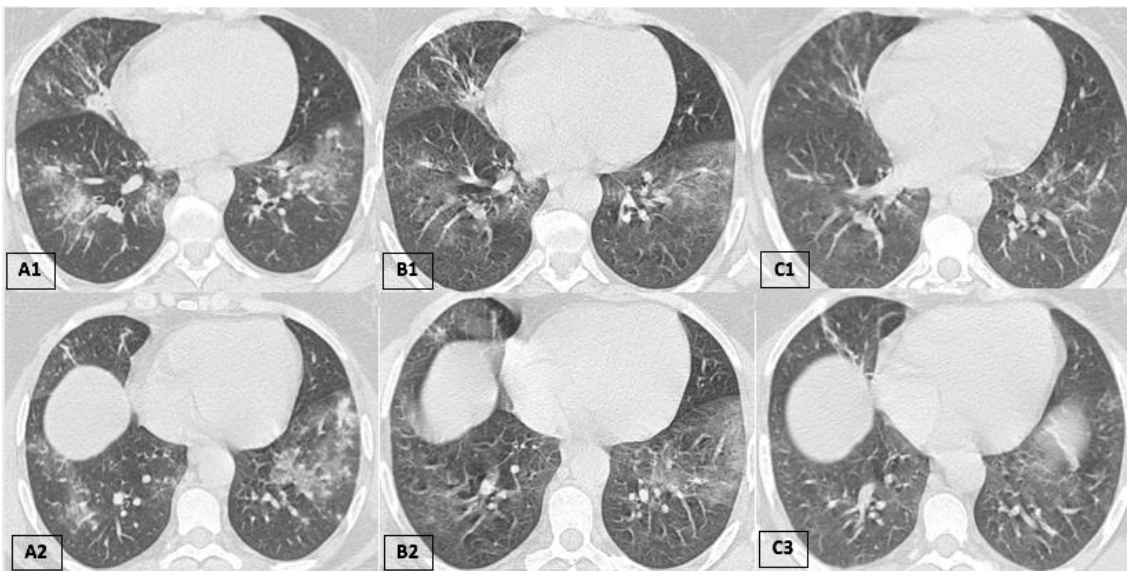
Axial non-enhanced lung sequences chest computed tomography at presentation in (A1,A2) and control CT respectively after 4 days in (B1,B2) and after 10 days in (C1,C2) , all images have the same window level and window width : (A1,A2) Bilateral diffuse peripheral and central ground glass opacities interesting the inferior lobes and the middle lobe associated to small bilateral consolidation areas progressively disappearing on control CT (B1,B2 & C1,C2).
